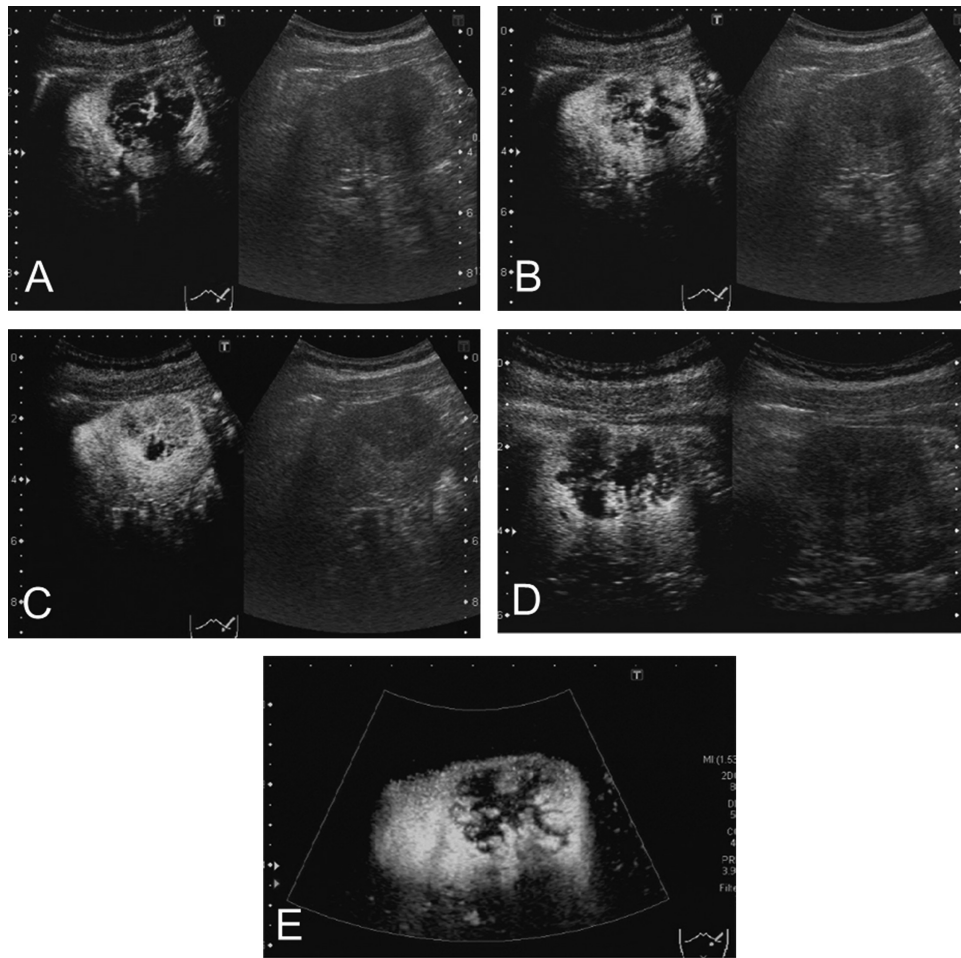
Contrast-enhanced ultrasound examination. (A) In the early vascular phase, a spoke-wheel-like enhancement extending radially from the center of the mass appeared at 12 seconds after administration of the contrast agent. (B) A densely enhanced portion then spread through the tumor. (C) Almost the whole tumor was enhanced after 23 seconds (D). In the postvascular phase, 15 minutes after injection, there is residual pooling of contrast agent in the periphery of the mass (E). The contrast-enhanced image is obtained after high acoustic pressure; insonation confirms the pooling of the contrast agent at the periphery of the mass.
